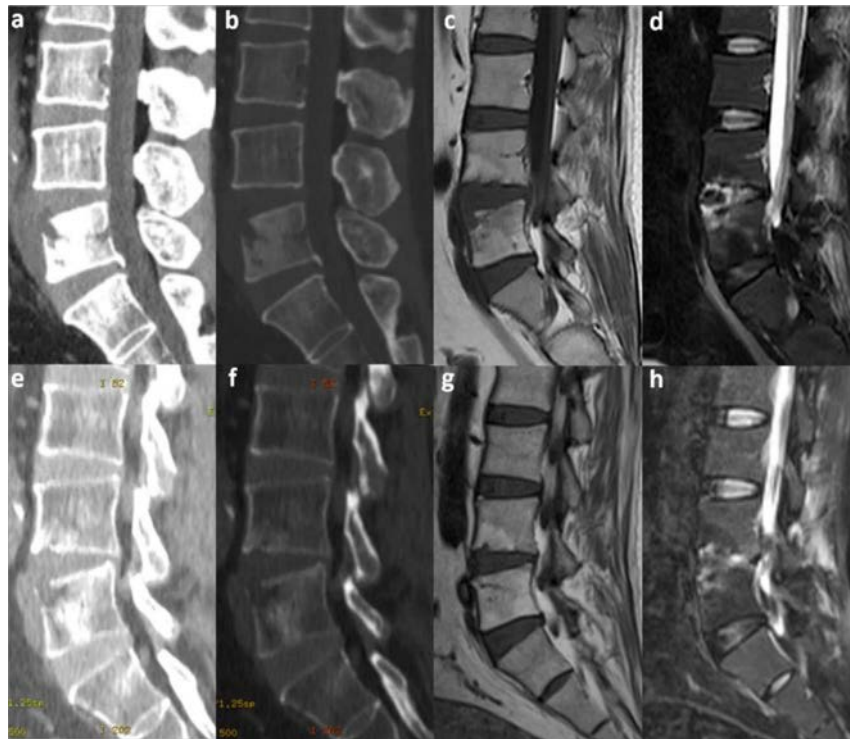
(a–d) showed the initial CT and MRI plain scans; increased bone density was seen in the anterior-middle part of L4-5 vertebra accompanied by focal bone resorption (a, b), the lesion presented as mixed low signal on T1-weighted image (T1WI) and mixed high signal on T2-weighted image (T2WI) (c, d), while the lesion involved the L4/5 intervertebral disc, with blurred edges and mild edema around (a–d). (e–h) showed the follow-up CT and MRI plain scans after three months of standardized treatment; the lesion of L4-5 vertebra was generally increased in density with a slightly shrunk area of bone resorption, of which the T1WI signal was increased, and the T2WI signal was mildly reduced. (a–h) All images are sagittal views: (a, e) CT image (soft tissue window), (b, f) CT image (bone window), (c, g) T1WI, (d, h) FS-T2WI.
